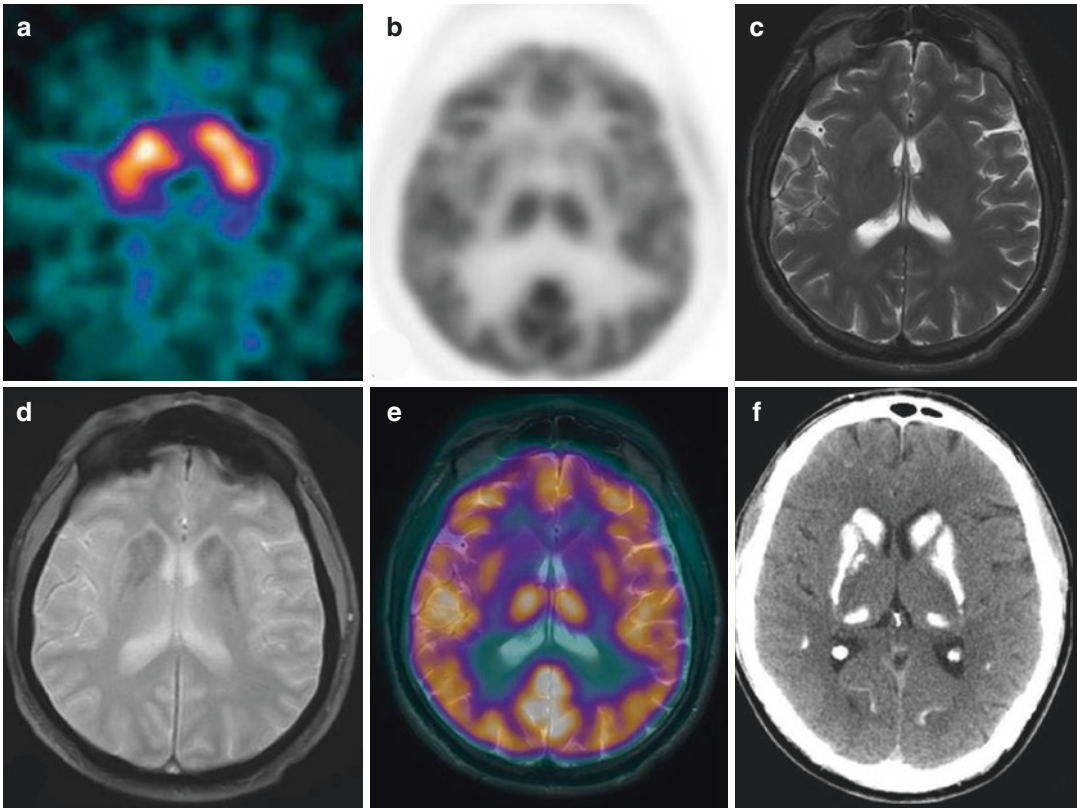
In a patient with ataxia and chronic headache, axial SPECT view with ¹²³I-ioflupane (a) shows regular tracer activity in the basal ganglia. The axial ¹⁸F-FDG PET view (b) displays hypometabolism in both caudate nuclei, in association with calcifications on T2 weighted
